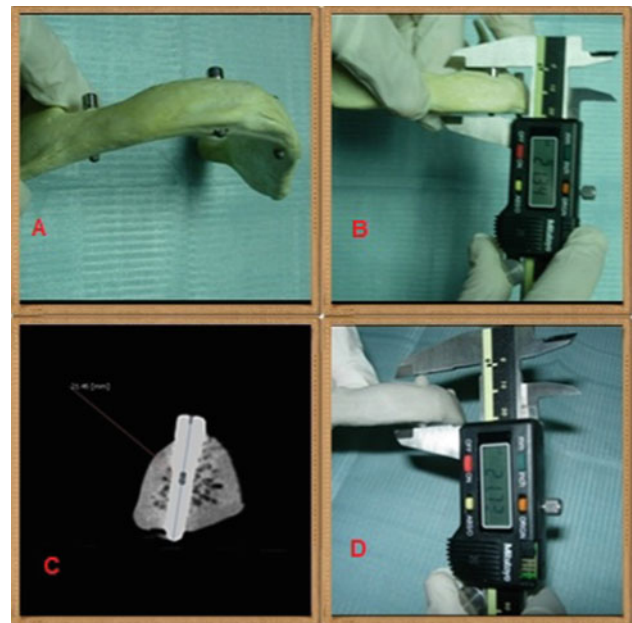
a The initial model with implants and healing caps in place. b Measurement using the digital caliper. c Measurement on the cone beam computed tomography image. d Measurement on the final model generated from 3D printing
